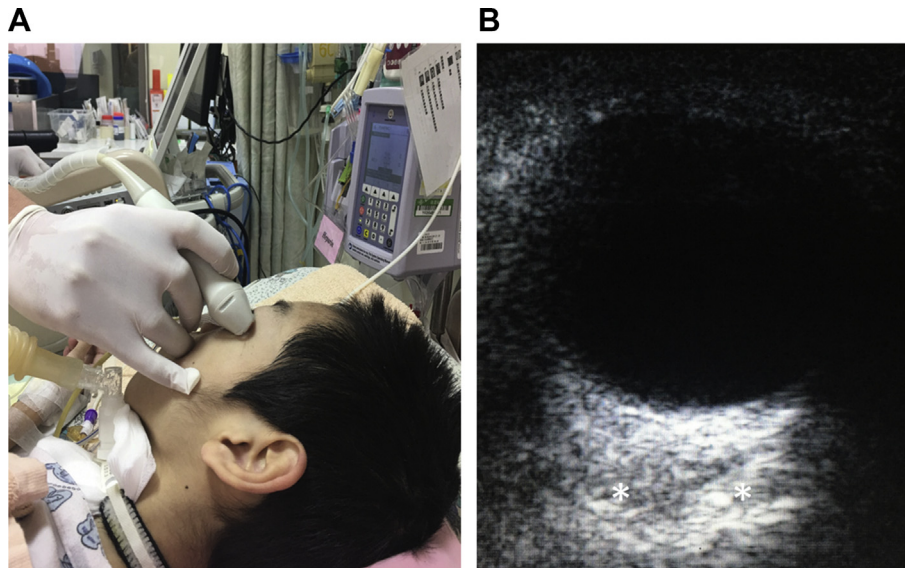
Technique and representative ultrasound images for a coronal approach. (A) Linear array transducer placed inferior to the closed eye to obtain a coronal image. (B) B-mode image showing a cross sectional cut of the optic nerve. (*..* ONSD: optic nerve sheath diameter).
